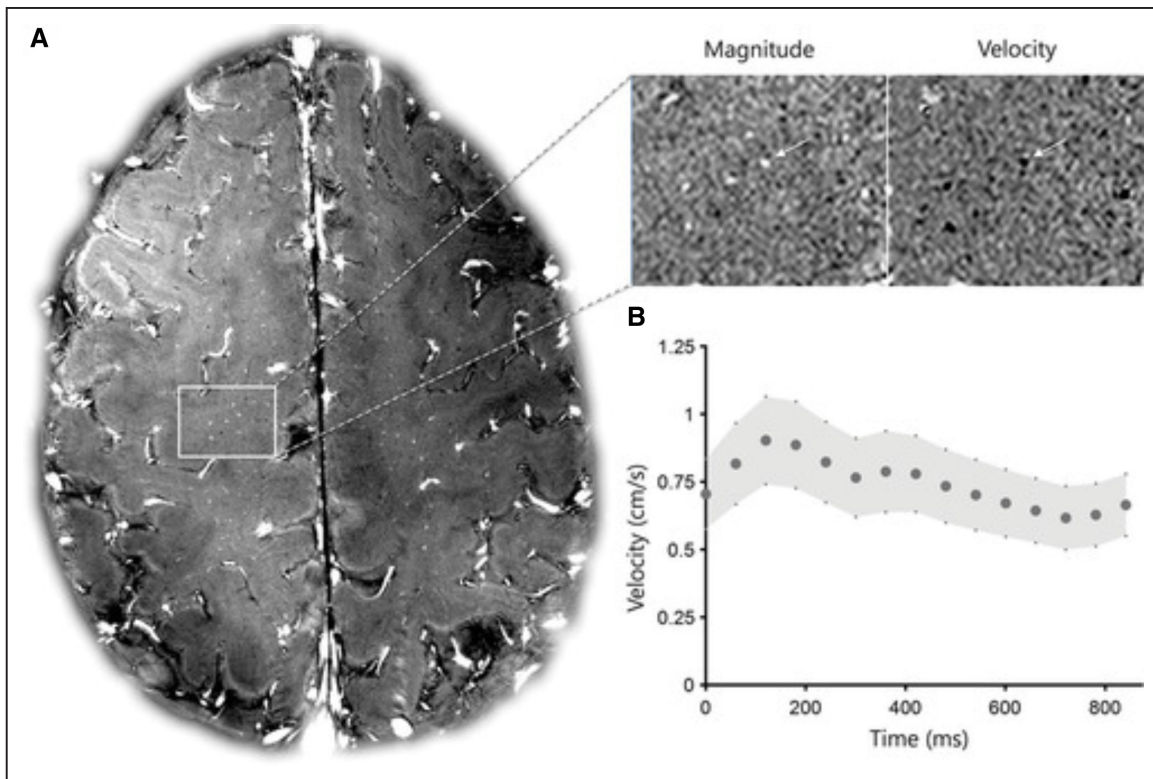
Blood flow velocity measurements in the centrum semiovale white matter perforators of a healthy human subject, obtained with high-resolution 2-dimensional phase-contrast magnetic resonance imaging (MRI). A, Mean magnitude image obtained over the cardiac cycle shows the perforators as hyperintense dots. Enlarged detail: magnitude and corresponding velocity map at single cardiac time point. B, Mean velocity-time curve over the cardiac cycle (average over all detected perforators [$n=55$]) and corresponding 95% CI. Maximum and minimal flow over the cardiac cycle can be used to calculate pulsatility index, a potential marker of small vessel stiffness. Reproduced from Zwanenburg and van Osch⁶⁰ with permission. Copyright ©2016, Wolters Kluwer Health, Inc.
